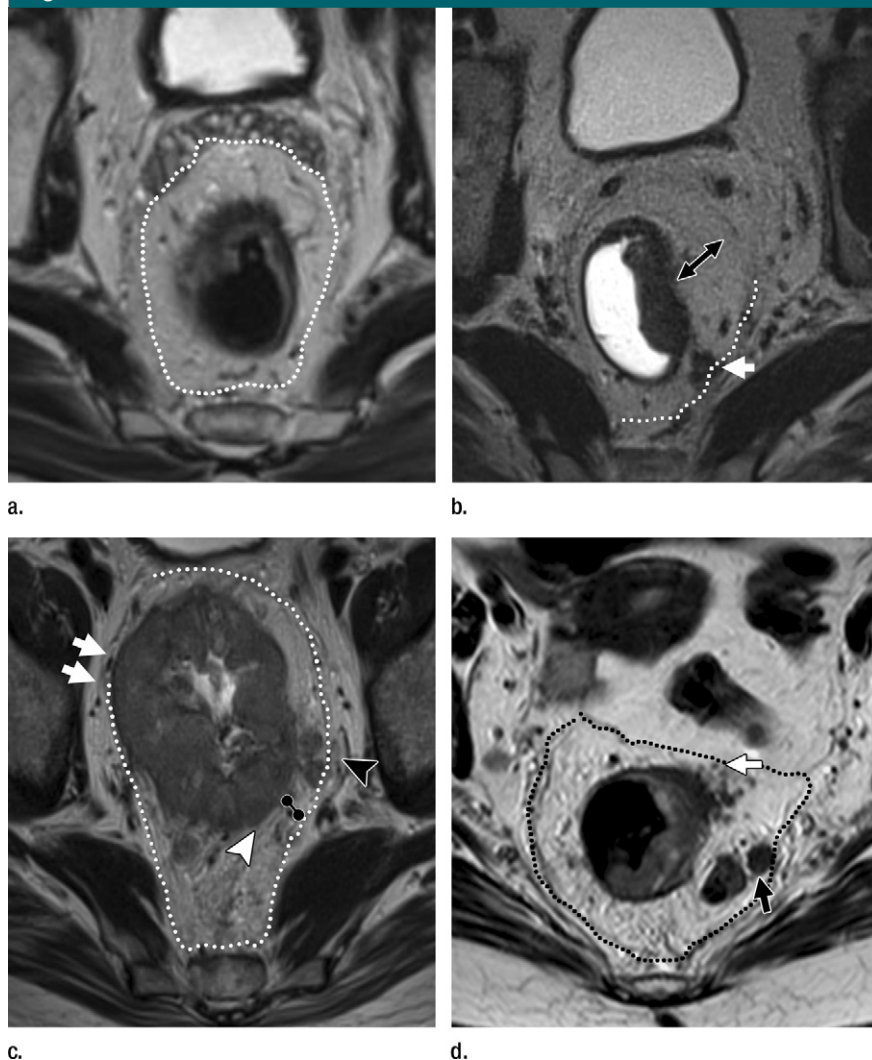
Axial T2-weighted images in different patients reporting the distance to the CRM and involvement of CRM. (a) Dashed line outlines the mesorectal fascia, which is the CRM in a T3a tumor with predicted clear CRM. (b) T3a tumor far away from the mesorectal fascia (black arrow). However, suspicious lymph node on the mesorectal fascia (white arrow) raises the possibility of potential CRM involvement (CRM = 0 mm). (c) T3d tumor confined within muscularis propria where the tumor is abutting the mesorectal fascia (arrows; at this level the tumor is T2). Invasive border appears to be posterolaterally on left (white arrowhead). The CRM regarding the tumor is evaluated at 5 mm. However, there are two mixed signal intensity lymph nodes (black arrowhead) abutting the mesorectal which leads to a CRM of 0 mm. (d) T3c tumor with EMVI bordering the peritoneum (white arrow) and irregular, heterogeneous signal intensity lymph nodes—there is tumor extension through the lymph node capsule, which is abutting the mesorectal fascia (black arrow) (predicted CRM = 0 mm).
